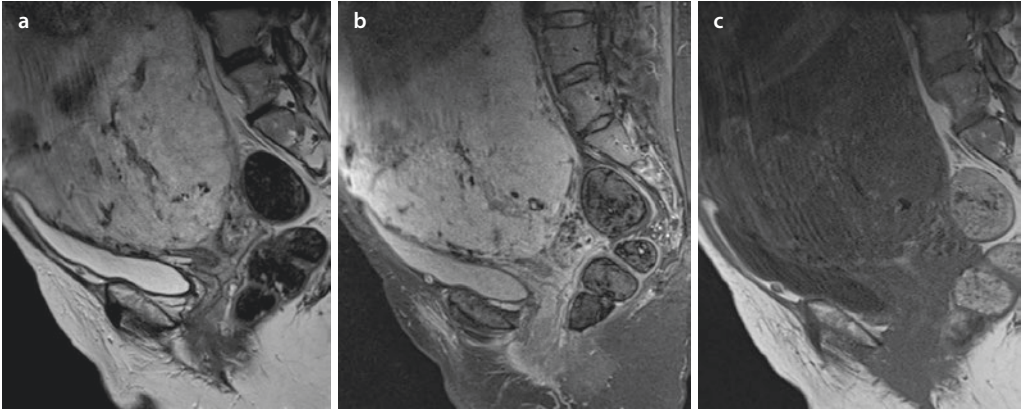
a–c Placenta percreta. Evidence of T2w hypointense vascular structures in the border region towards the urinary bladder. These are best delineated in the T2-weighted sequence with fatty saturation, whereas in the T1w the vessels cannot be identified.
